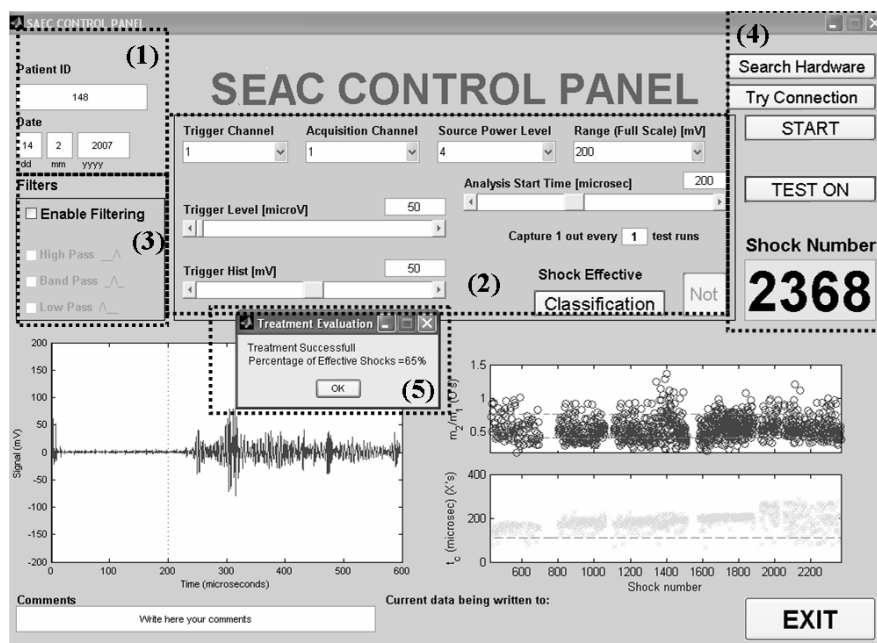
A screen shot of the output of the SEAC software interface used by the ESWL operator during phase 2 of the project. The dotted lines demarcating numbered boxes have been added to identify areas in the display (see text for details). Box 5 gives an indication of the percentage of the 2368 shocks given in this treatment which were effective at damaging the stone (TS_0). A score here of 65% indicates a successful treatment. The values of the acoustic parameters (m_2/m_1 and t_c) for each shock are shown in the graphs on the bottom right hand side of the interface, allowing trends to be noted. The bottom left panel plots the echo time history of the most recent shock, to allow assessment of the extent to which it conforms with the expected structure (noting however from Leighton *et al.* [13] that visual inspection is not as reliable at spotting two-burst structures as plots of the energy time history). In addition to these, there are three other display outputs from SEAC, and these are particularly important. The first of these is the treatment score TS_0 obtained at the end of the treatment (Box 5, described above); the second is the cumulative ratio $TS(t)$ of effective shocks to the total number of shocks given from the start of the treatment to any point during it (which equals TS_0 at the end of treatment); the third indicator is the red/green indicator light which provides feedback on the most recent shock. Trends in these are available (e.g. via the two graphs on the bottom right of the screen). Figure reproduced with permission from reference [13], where it previously appeared: *Ultrasound in Medicine and Biology* doi:10.1016/j.ultrasmedbio.2008.03.011 in press (by T. G. Leighton, F. Fedele, A. J. Coleman, C. McCarthy, S. Ryves, A. M. Hurrell, A. de Stefano, and P. R. White) “A device for monitoring the efficacy of ESWL using passive acoustic emissions, Copyright Elsevier 2008.
